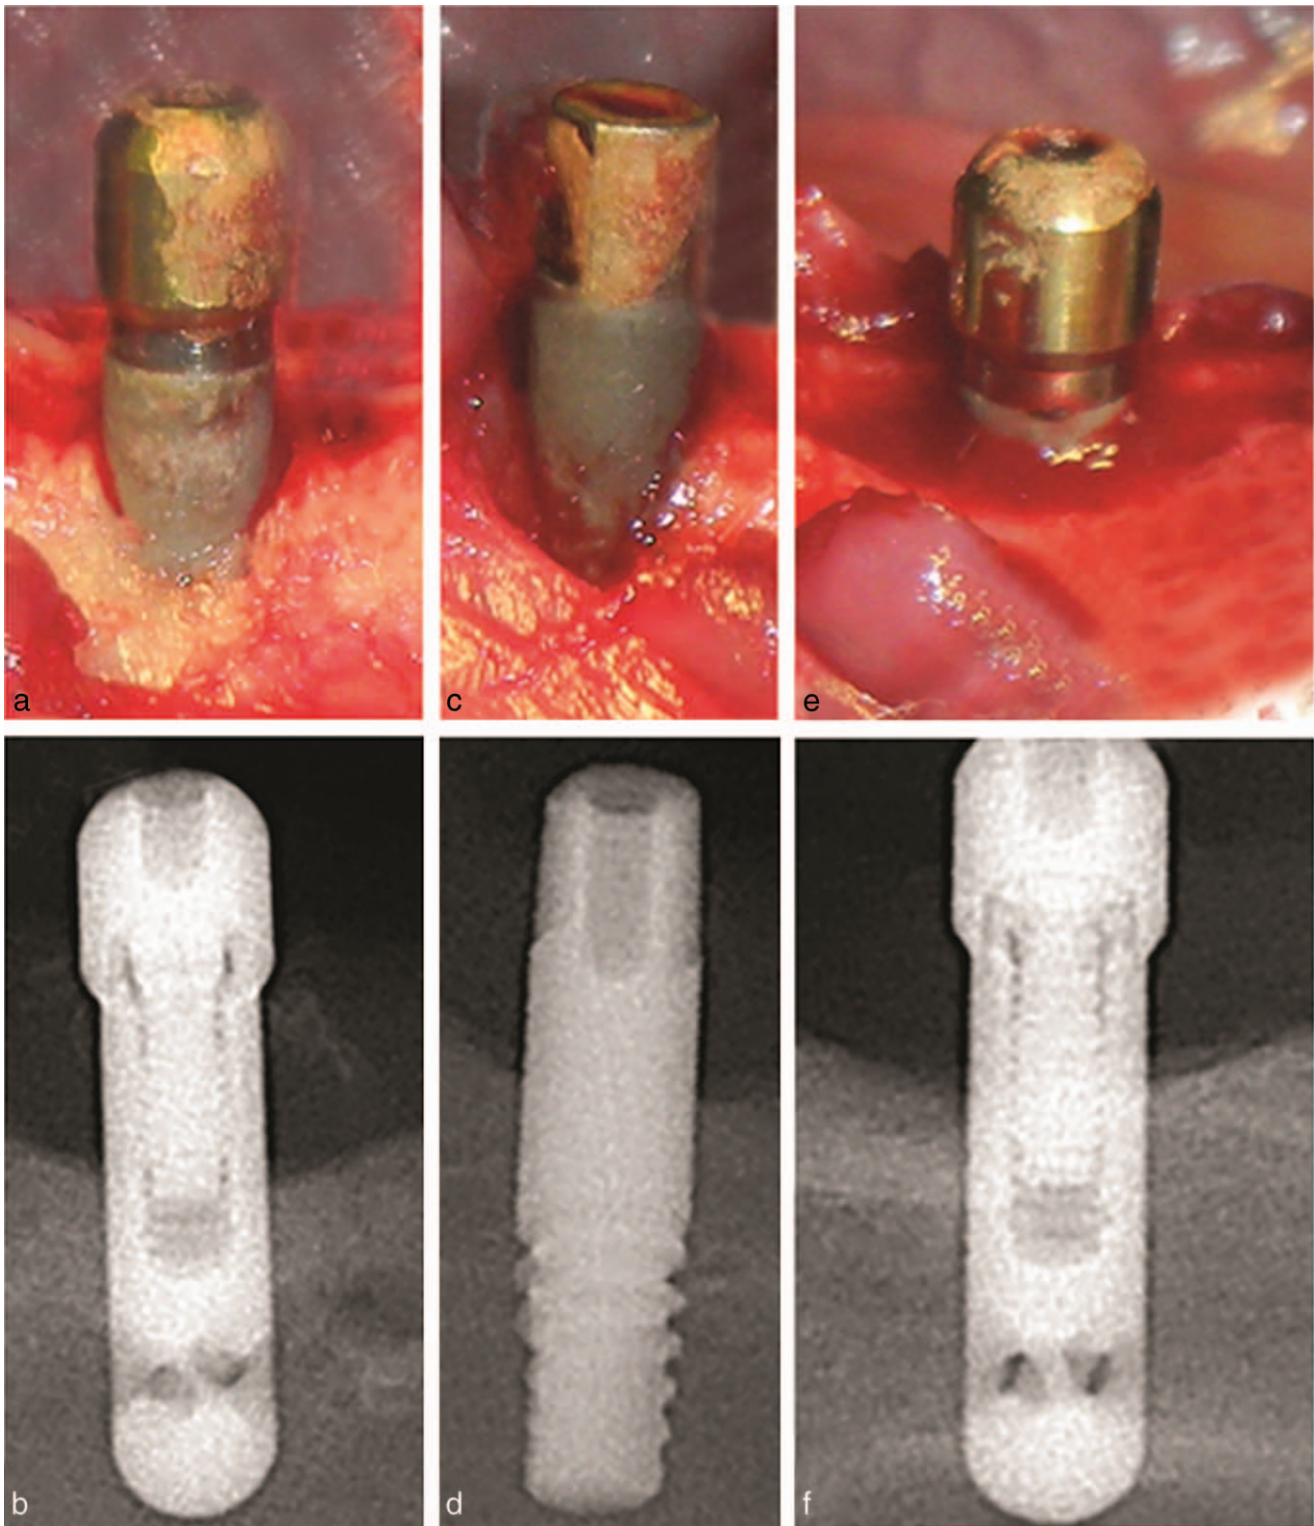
Clinical and radiographic view of induced peri-implantitis defects around different implant types. (a and b) Class III defect around plasma-sprayed hydroxyapatite (HA)-coated implant (type P). (c and d) Class III defect around sandblasted acid-etched implant (type SA). (e and f) Class II defect around plasma-sprayed HA-coated implant showing wide horizontal defect width.
